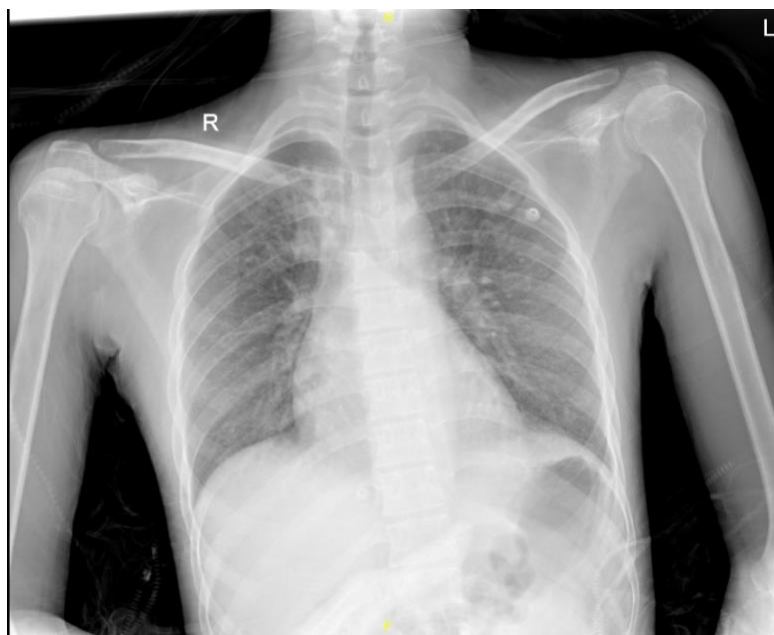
Patient Chest X-ray in AP (anteroposterior) view showed suprahilar and apex patchy infiltrate and prominent bronchovascular markings in both lungs
